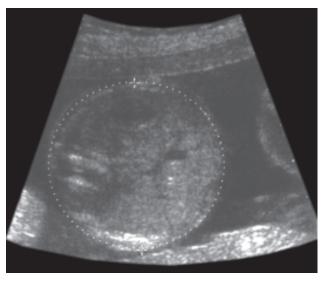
Ultrasound image demonstrating the abdominal circumference measurement in a second trimester fetus
